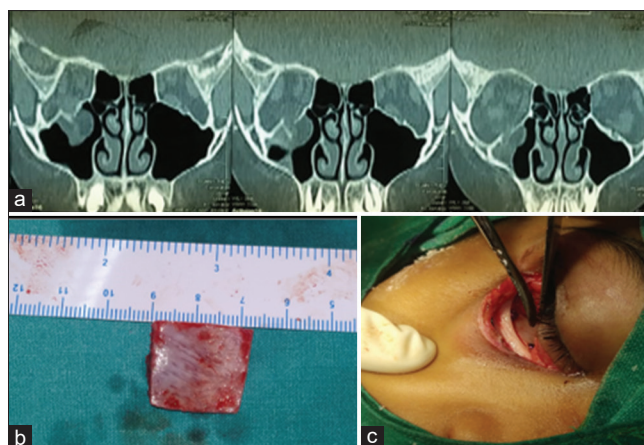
(a) CT-axial view with hanging drop appearance, (b) The harvested iliac crest graft, (c) Fixation of the autologous graft to orbital floor
